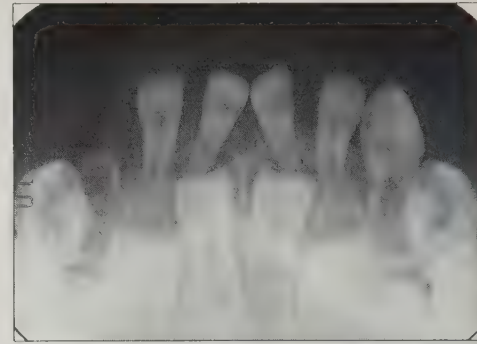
Mandibular anterior occlusal radiograph.
